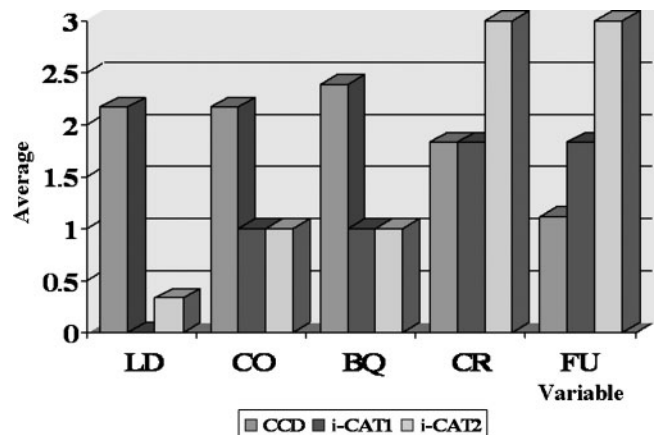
Quality assessment: variable comparison for the charge-coupled device (CCD) ratings and the two cone beam CT (CBCT) ratings. The lamina dura (LD) were well delineated on the CCD images and (almost) not visible on CBCT. CCD also scored better for the variable contrast (CO) and bone quality (BQ), but only periodontal craters (CR) and furcation involvements (FU) were better visualized on CBCT cross-sectional slices (i-CAT2) compared with CCD or CBCT panoramic reconstruction images of 5.2 mm (i-CAT1)
